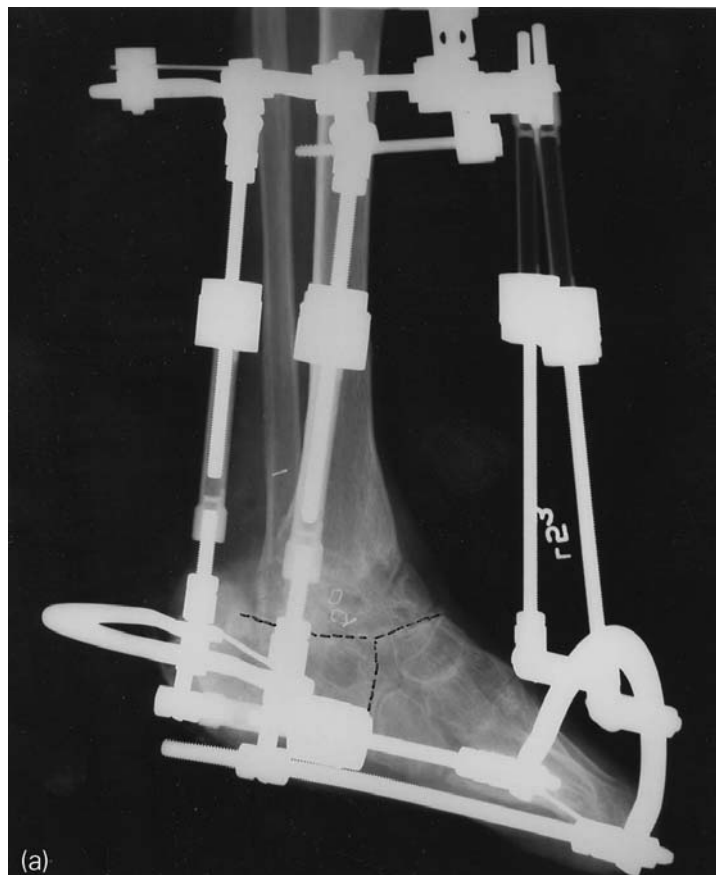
This is the same patient shown in Figure 13.2. The patient had bilateral deformities. This is the patient's left foot with recurrent equinovarus deformity. The original equinovarus deformity was corrected and the joint was fused to maintain the correction; however, the deformity recurred through the talar/navicular joint. (a) Lateral radiograph taken after surgery. A Y-shaped osteotomy (dotted line) was performed (Figure 0.8) through the talar/navicular, calcaneus, and talar/calcaneal areas. (b) Clinical photograph taken after surgery showing the apparatus. Correction of equinus occurs as the calcaneus is distracted via the posterior arm of the Y-shaped osteotomy. Cavus correction occurs through the anterior arm of the Y-shaped osteotomy by distracting the medial telescopic rods.
